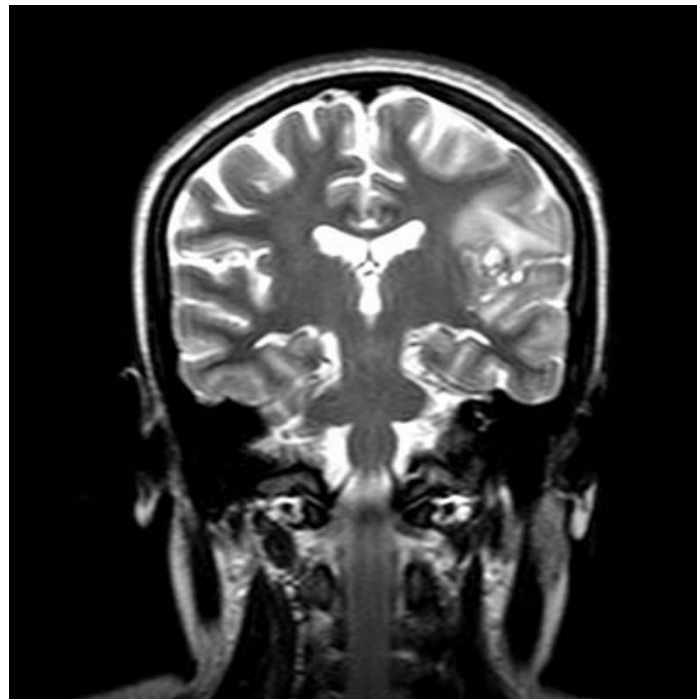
Control (six months later) T2 W coronal MR images showing no changes in cystic lesion and periedema
